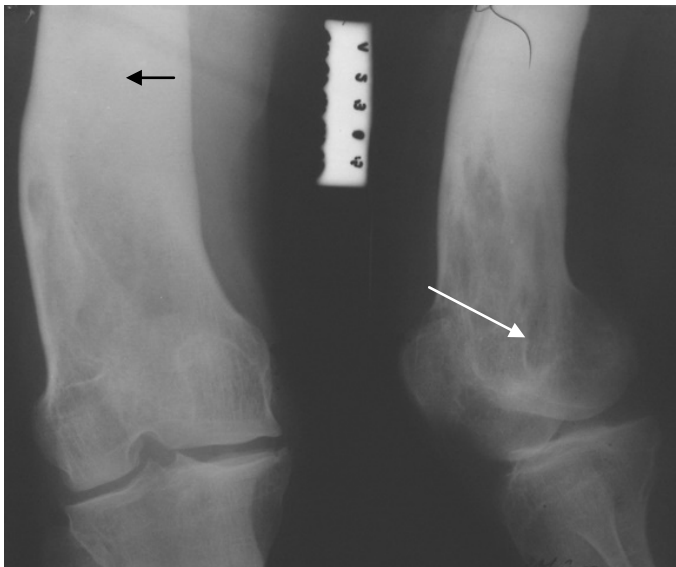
Radiograph of the hip in direct and lateral projections. Hyperostosis of the femur: the femur in the lower third of diaphysis (a black arrow) and distal epiphysis is deformed, densified (osteosclerosis), and increased in sizes. Sites of destruction in distal metaphysis (a white arrow) are detected as well. Chronic osteomyelitis of the femur
